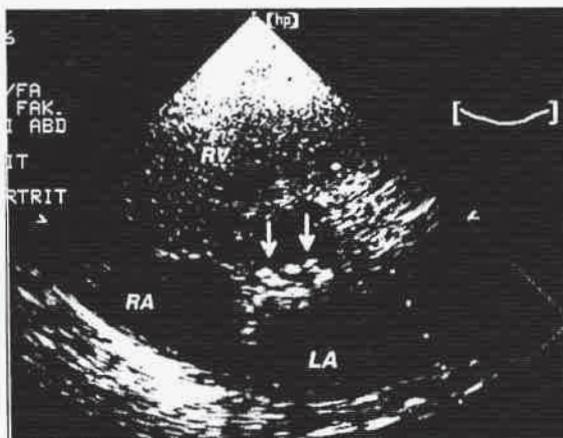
Three nodules on two cusps of the aortic valve (arrows) of a 75-year-old female patient with rheumatoid arthritis (parasternal short axis view). The nodules were on the aortic side of the valve. RV: right ventricle, RA: right atrium, LA: left atrium.
